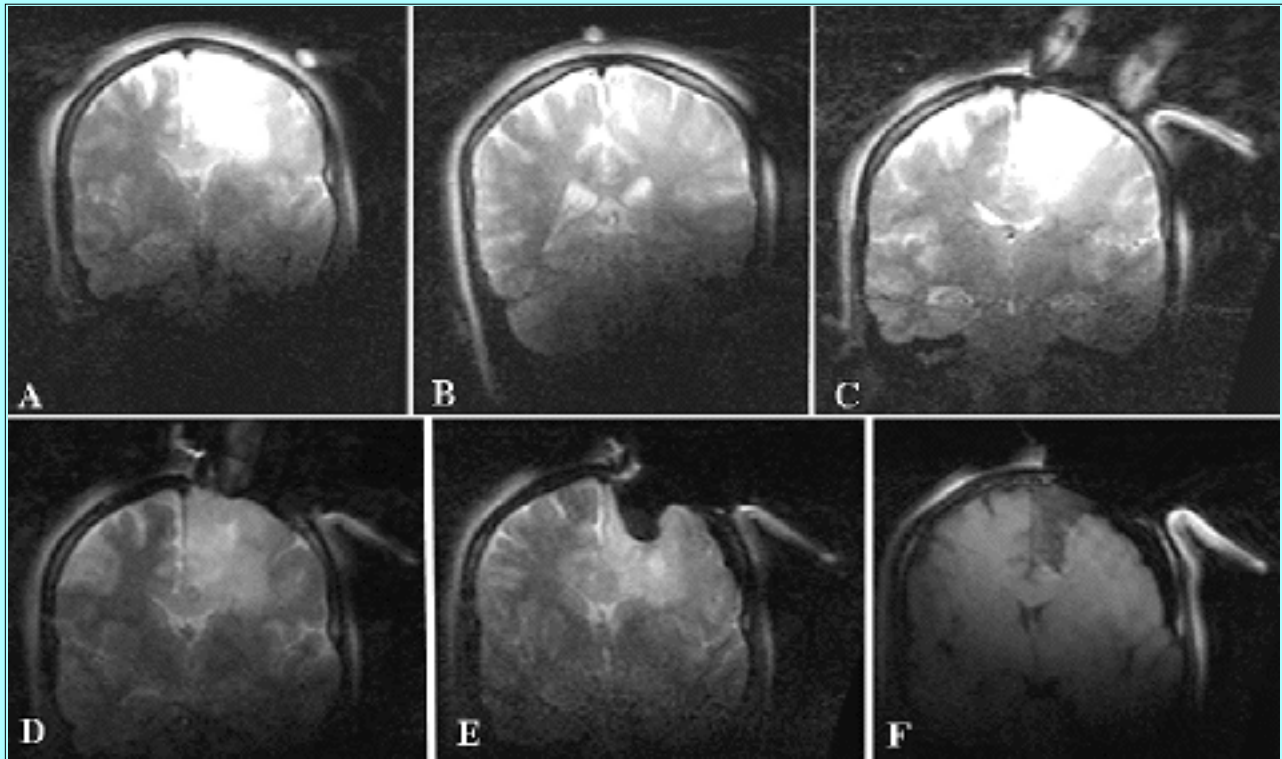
Intraoperative coronal MR images obtained in a patient with a parasagittal frontal mass. A: A T₂-weighted image of a bead placed on the skin to establish the lateral edge of the planned craniotomy. B: A T₂-weighted image of the posterior aspect of the tumor and a bead over the midline (several slices posterior to A in the same series). C: A T₂-weighted image of finger localization prior to dural opening. D: A T₂-weighted image showing localization of optimal corticectomy. E: A T₂-weighted image obtained to evaluate the lateral margin during resection. F: A T₁-weighted image obtained after dural closure to evaluate any hemorrhage in the surgical bed.
